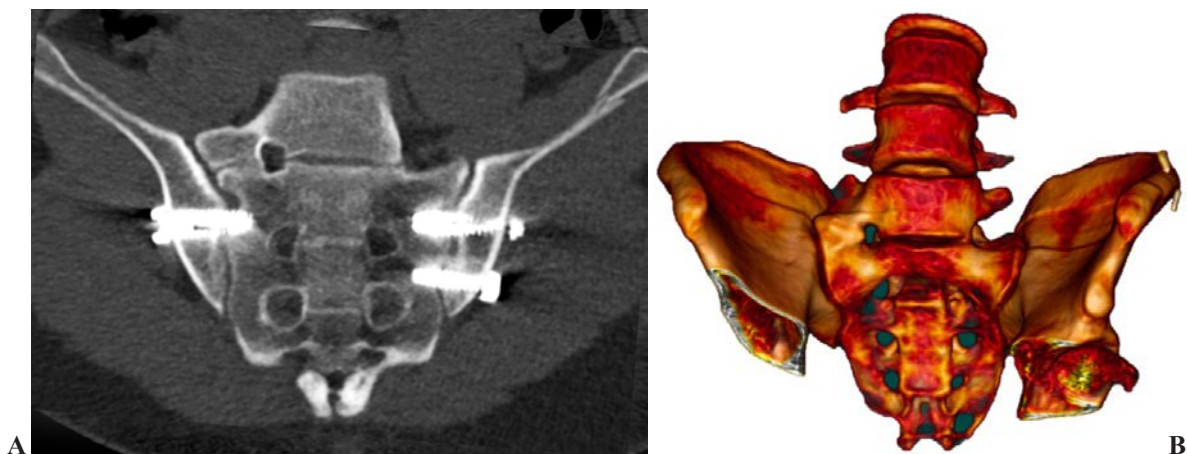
Right L5 emisacralization in a patient with transitional vertebra and bilateral sacroiliac pain. On 3D CT recons there's evident fusion between the right L5 hemivertebra and the ipsilateral sacral wing, concurring to the asymmetrical loadstress and SIJ disease development (2a). Bilateral SIJ fixation putting 2 screws on regular left side, one at the S1 level and the second at S2, and a third contralateral screw at S1 level were introduced, resolving the clinical symptoms related to the disease (2b).
